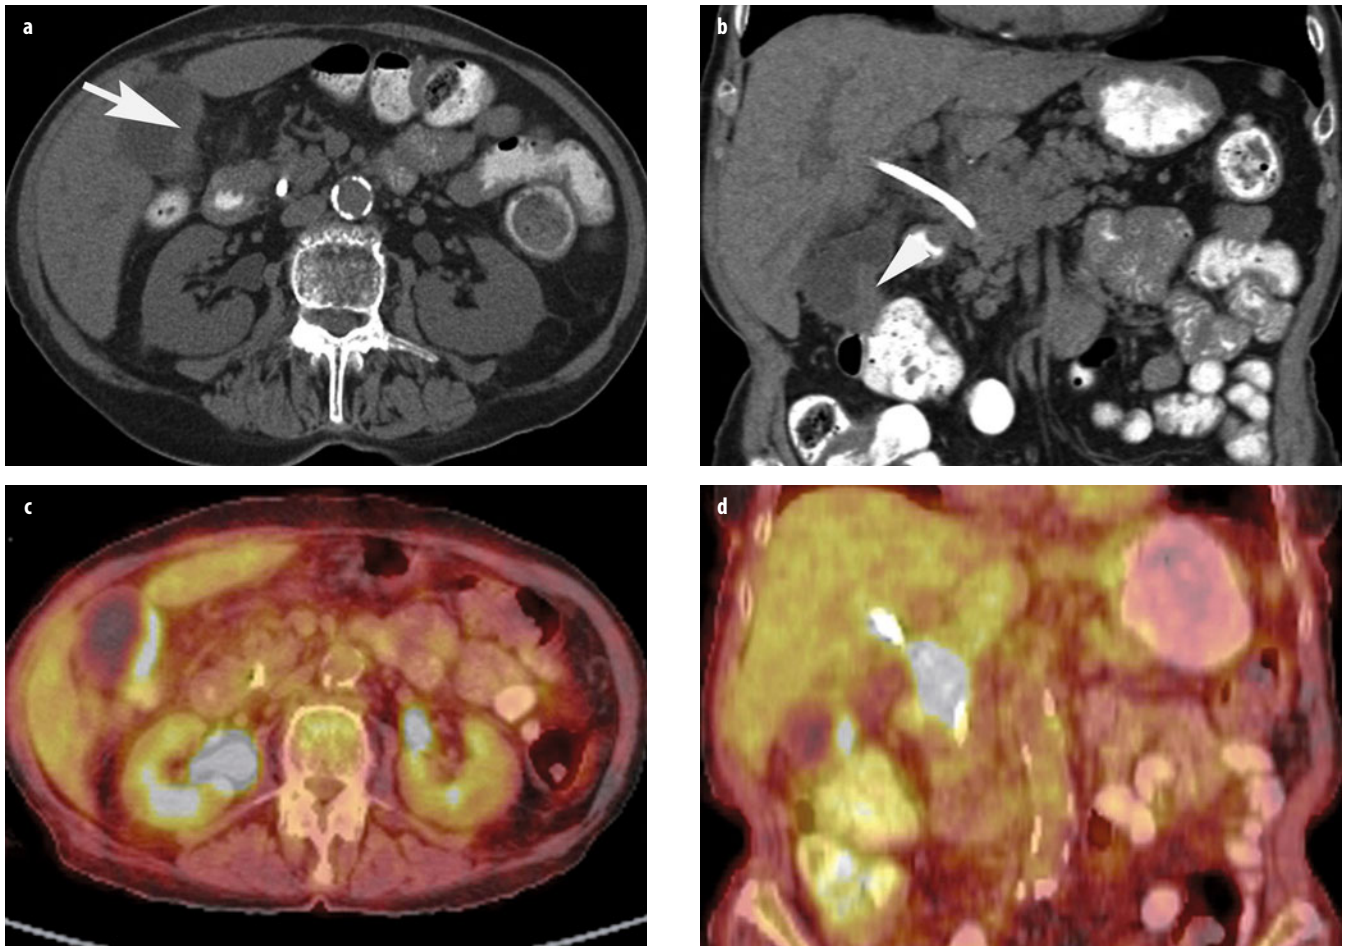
a-d. Gallbladder carcinoma. a, b Contrast-enhanced computed tomography (CT) using orally administered contrast medium shows focal gallbladder wall thickening (a, *arrow*) with irregular margins that extends to invade the adjacent transverse colon (b, *arrowhead*) and hepatoduodenal ligament. A bile duct stent is in place. c, d Fluorine-18-deoxy-glucose ($[^{18}\text{F}]$ -FDG) positron emission tomography computed tomography (PET-CT) shows metabolically active gallbladder wall thickening and a mass encasing the common bile duct that most likely represents metastatic disease
